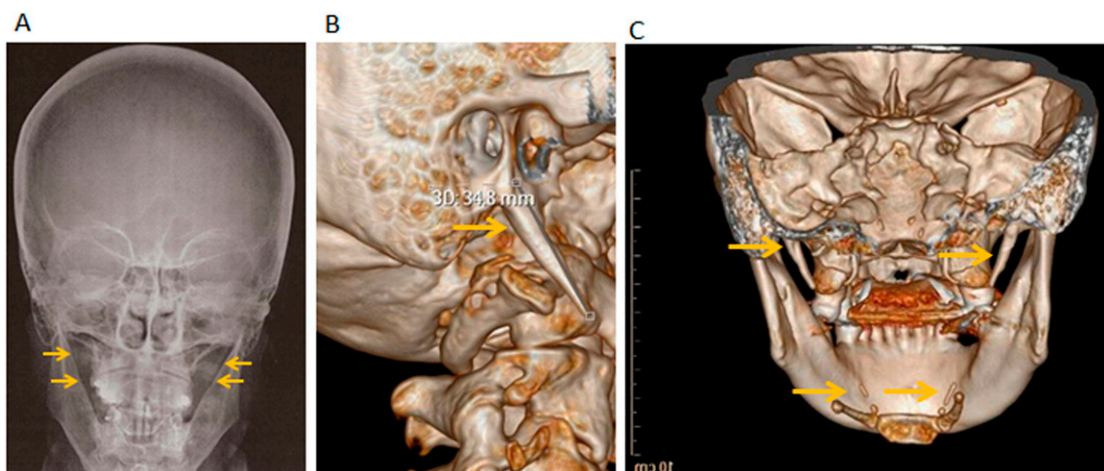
Representative radiological findings showing calcification of the SHL in different patients with TS. Arrows identify the prolonged and calcified SHL. The standard measure of SHL is <25 mm. (A) Frontal cranial simple X-ray showing an SHL >40 mm. (B) 3D CT sagittal cranial view evidencing an SHL of 34.8 mm. (C) Frontal cranial CT showing an SHL of 29 mm on the right and 23 mm on the left side.
